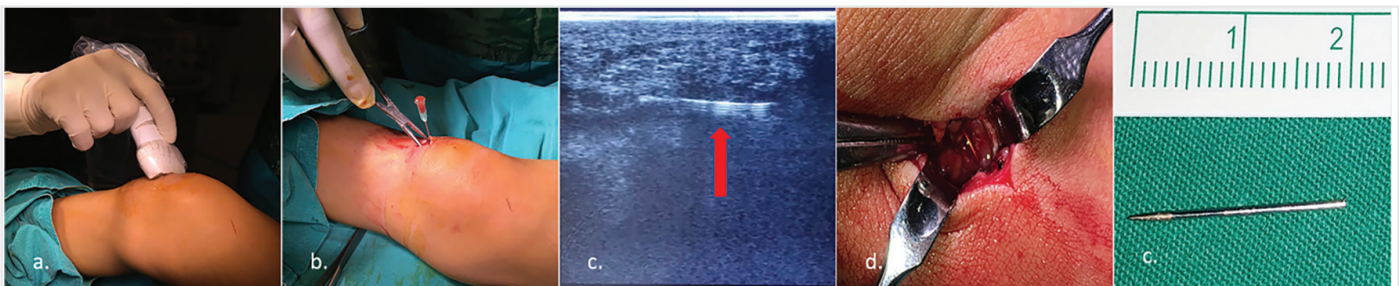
Ultrasound-assisted foreign body (needle) removal from the anterior part of the knee, (a, b) Localization of needle under USG guidance, (c) Red arrow show the needle, (d) Approximately 13 mm skin incision, (e) Removed needle. (Written informed consent is taken from the patient)
